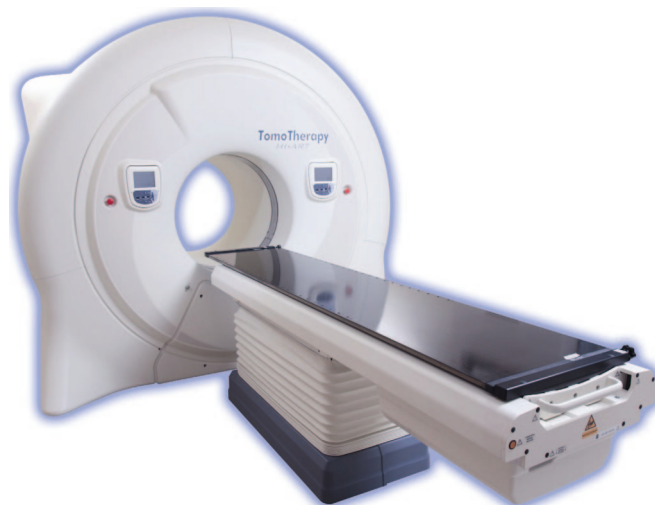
Tomotherapy unit. Helical tomotherapy includes IMRT delivered as the linear accelerator rotates around the patient in a continuous helix. This is performed with a linear accelerator mounted in a manner analogous to a CT scanner. (Provided by and reproduced with permission of TomoTherapy, Inc., Madison, WI.)
